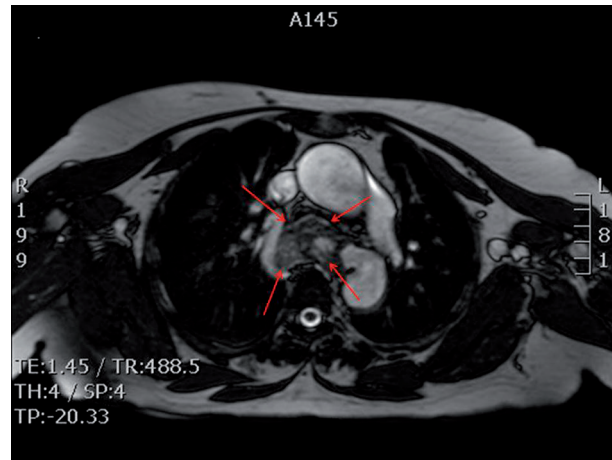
T2 weighted MRI image of the mediastinum on which a bilobular mass is seen (3,8 cm x 4,6 cm x 6,4 cm) (arrows). The lesion is heterogenic hypo and hyper echogenic on T2 weighed imaging. The esophagus is displaced to the right. The trachea is ventrally displaced. After injecting IV gadolinium (image not shown) a small part of the mass showed equal intensity than the adjacent descending thoracic aorta allowing the diagnosis of a largely thrombosed aortic aneurysm to be made.
